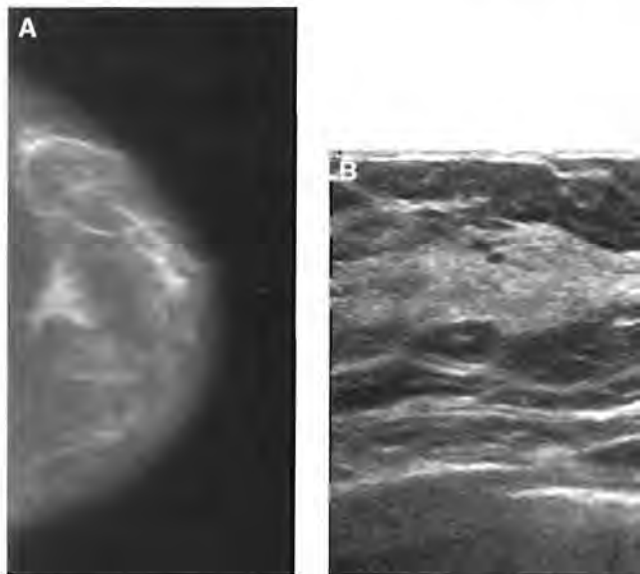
Correlating mammography and US. (A) Craniocaudal mammographic view shows triangular focal asymmetry in central posterior breast. (B) Sonogram shows triangular fibroglandular area with fat anteriorly and posteriorly. Allowing for upright mammographic position and supine position for US, the size, location, and tissue pattern correspond.
